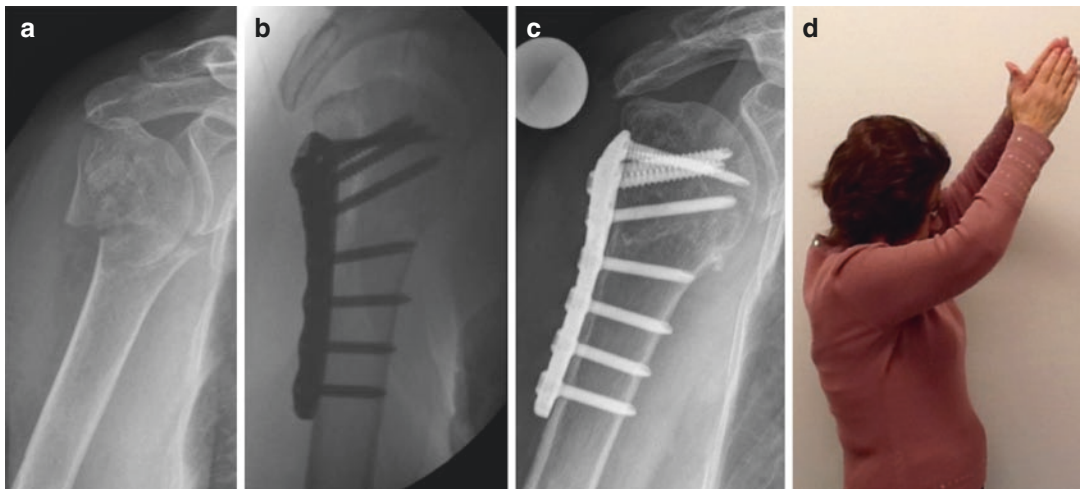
(a) AP radiograph of a not impacted 2-part surgical neck fracture of a 65 y.o. female with limited bone quality (DTI < 1.4). The indication to ORIF was made according to the algorithm. (b) direct postoperative radiograph after angular stable ORIF. (c) AP radiographic follow-up after 1 year. (d) Clinical result (forward flexion) after 1 year
